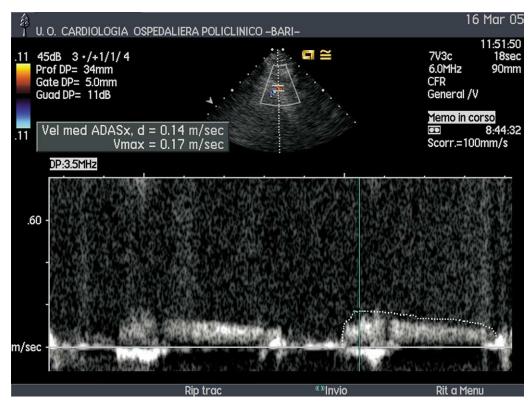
Coronary flow velocity in the left anterior descending coronary artery measured with posterior wall Doppler echocardiography.). It is possible to measure the mean and maximum velocity of the different components of coronary flow (the diastolic contour is outlined).
